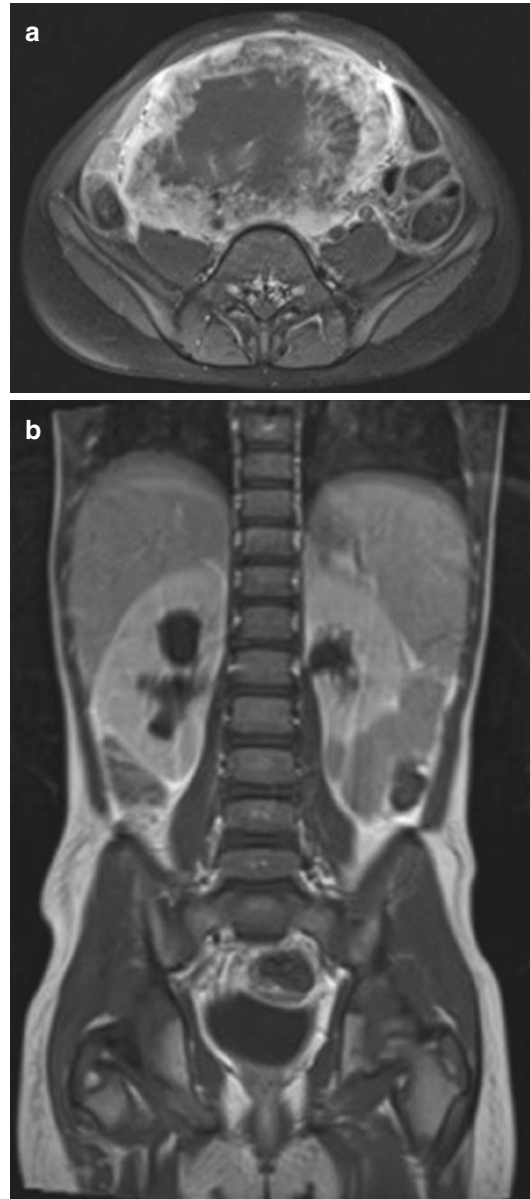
Supraventricular rhabdomyosarcoma in a 4-year-old boy. T1-weighted MRI post-Gd shows an enhancing tumor with central necrosis (a). The close relationship of the tumor with the ureters causes bilateral hydronephrosis (b)
